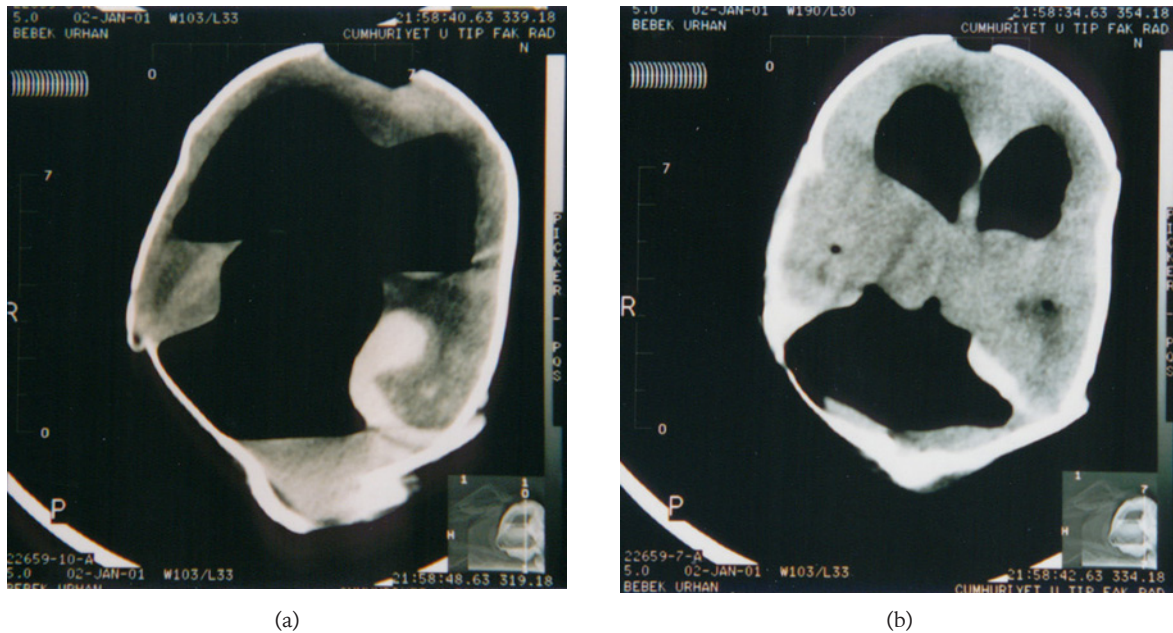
Axial cranial CT: a), b); Occipital encephalocele, cystic dilatation of the 4th ventricle, cerebellar hypoplasia, cerebellar vermis agenesis, hydrocephaly.
